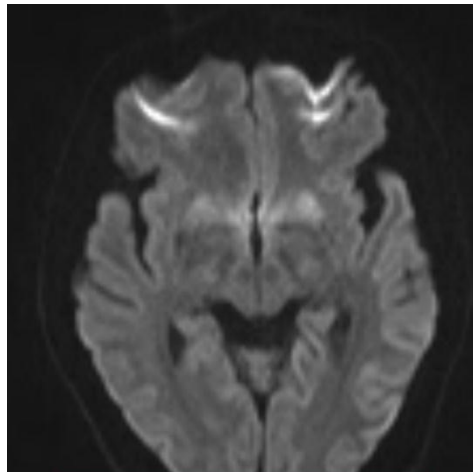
Diffusion Weighted Imaging (DWI) Sequence of Bilateral Frontal Cortex
